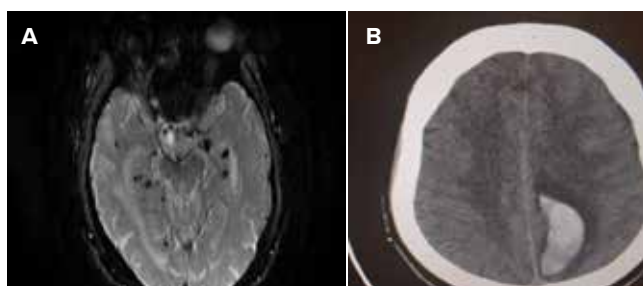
A) Susceptibility weighted imaging (SWi) in magnetic resonance imaging (MRI) showing multiple areas of blooming suggesting microhaemorrhages B) Computed tomography (CT) scan suggestive of lobar haemorrhage (Images courtesy Dr. Man Mohan Mehndiratta).
